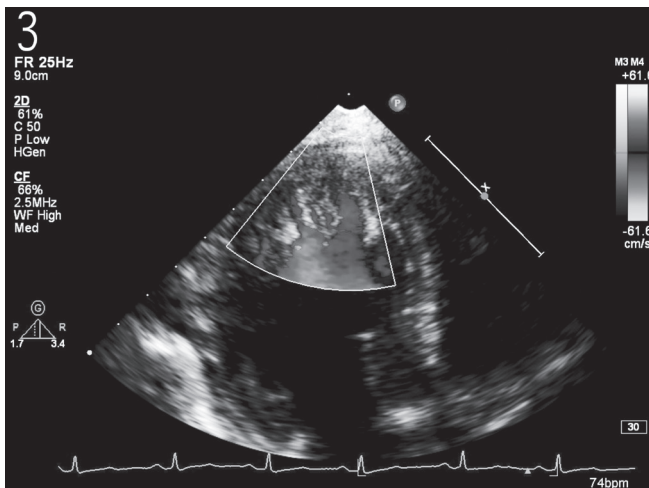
Apical two-chamber in diastole demonstrating flow within the trabeculae.
